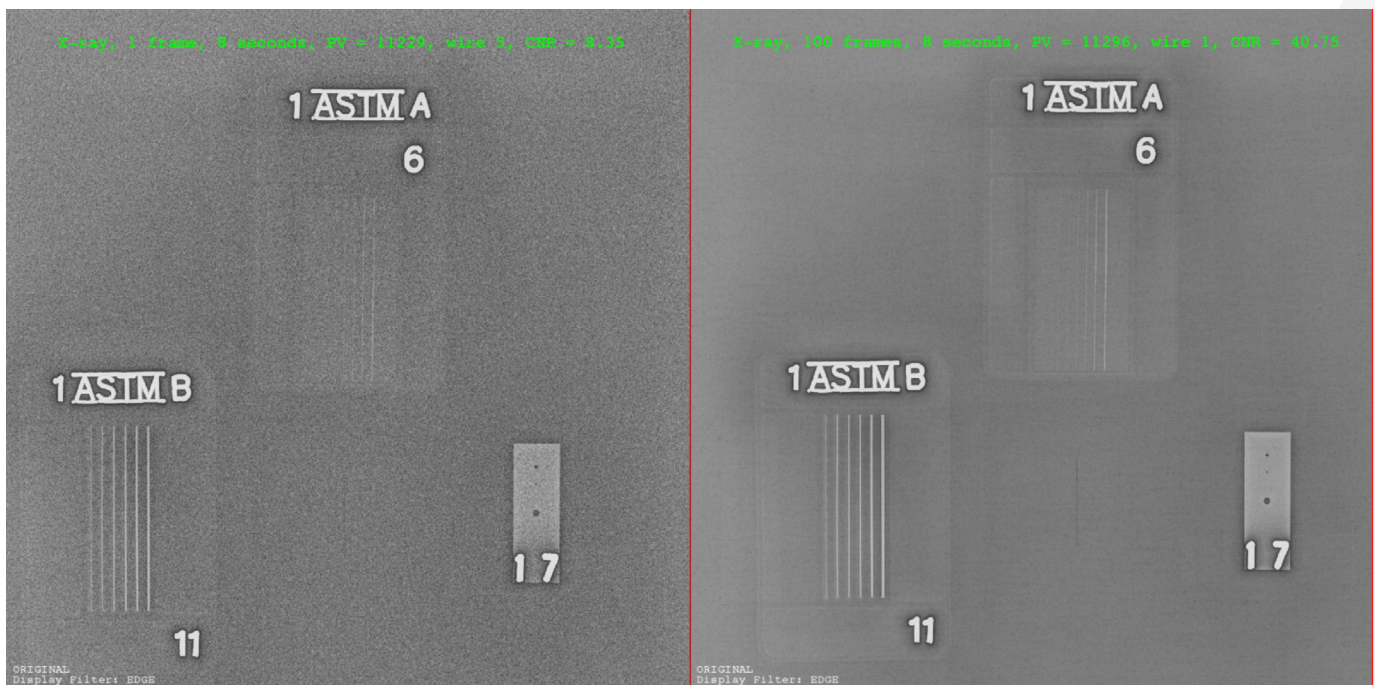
Comparison of Averaged Frames for the HPX-DR 3543. It presents a visual comparison of averaged frames for X-ray. The image on the left was at 1 frame, 8 seconds integration time, pixel intensity of 11229, 5 wire visible, contrast-to-noise ratio CNR of 8.35. The image on the right was at 100 frames, 8 seconds integration time, pixel intensity of 11296, 1 wire visible, contrast-to-noise ratio CNR of 40.75.
